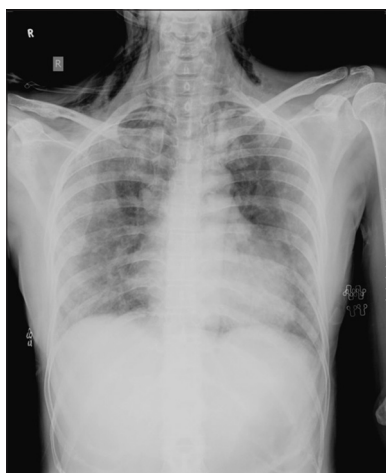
Mediastinal emphysema and diffuse haziness in chest X-ray
